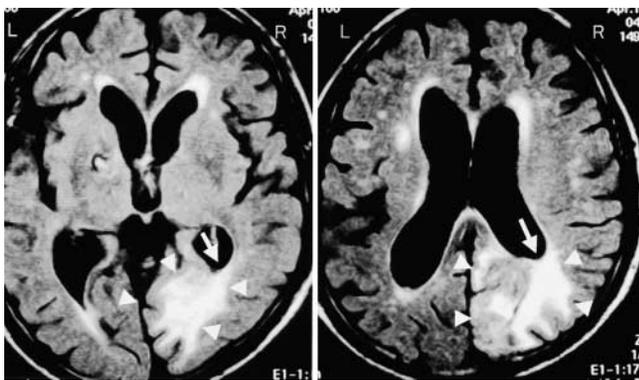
Axial fast low-angle inversion recovery magnetic resonance images of the brain obtained 1 month after symptom onset clearly demonstrating a large right occipital infarction (*arrowheads*), as well as the damaged ependyma of the right posterior horn (*arrows*).
